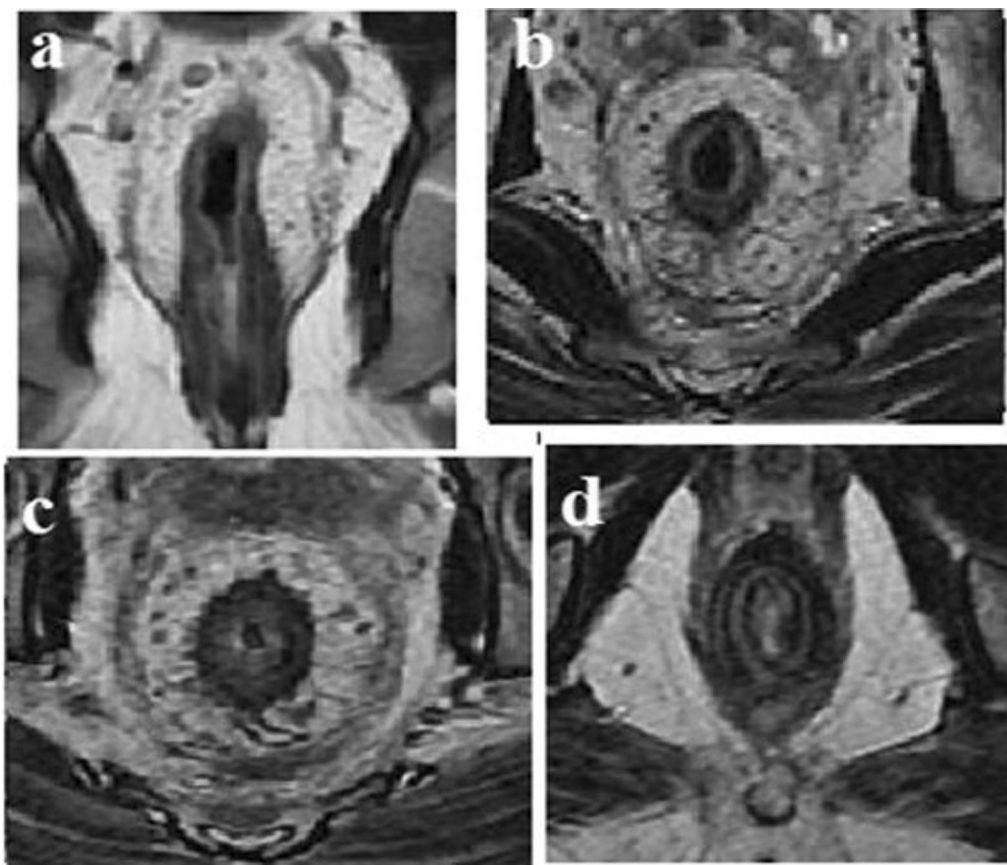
a–d MRI study for a 39 years old male with anorectal mucinous carcinoma and received CRT. Coronal (a) and Axial (b–d) T2 WIs, revealed circumferential diffuse hypointense signal of the rectal wall/anal canal with mild submucosal hyperintense T2 signal (interpreted as post-therapy fibrotic changes with mild submucosal edema). Stranding appearance/smudging of the mesorectal fat planes and mildly thickened hypointense mesorectal fascia. Intact external anal sphincters and levator ani
